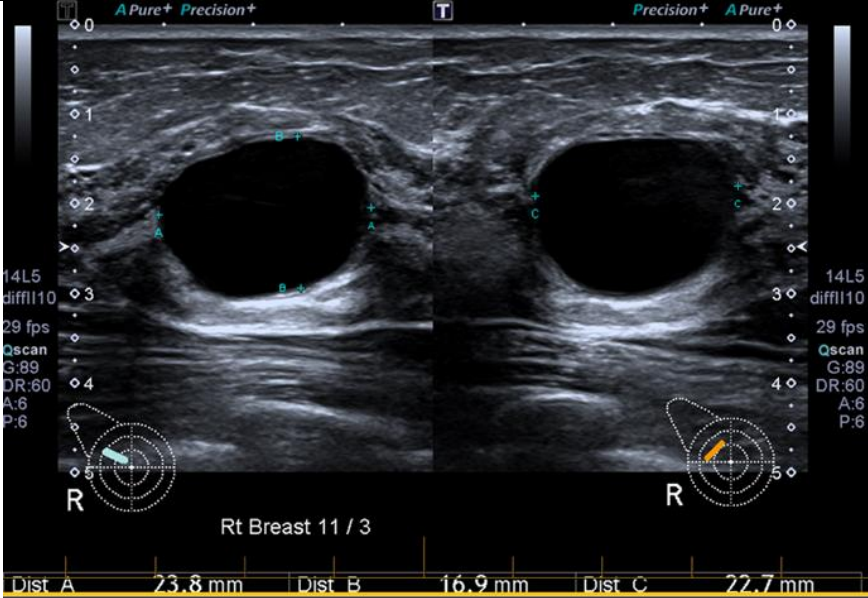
Ultrasound image of a breast lesion correctly annotated in accordance with the current Standards of Practice for Breast Imaging. Image used with permission from author's workplace, 2023.
